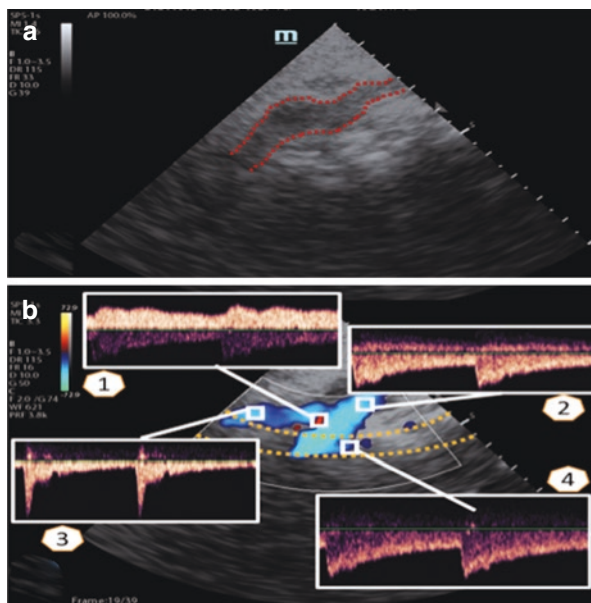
Submandibular window in B-mode and color-coded Doppler ultrasound. (a) B-mode image at submandibular level indicating the hypoechoic area (red dotted line) corresponding with the carotid artery. (b) Color-coded Doppler and pulsed-Doppler ultrasound at the same level above. As the direction of the transducer is pointing in cranial direction, carotid artery flow direction is away the probe. Small red area at the carotid bifurcation level corresponds to the jugular vein (flow direction toward the transducer). Different spectral-Doppler waves are shown in order to identify the vascular structures. 1: jugular vein; 2: common carotid artery; 3: external carotid artery; 4: internal carotid artery. Orange dashed lines were sketched between 40 and 60 millimeters to prove the correct depth of insonation to proper measurement of the internal carotid artery. (Author: Jorge Carrizosa)
